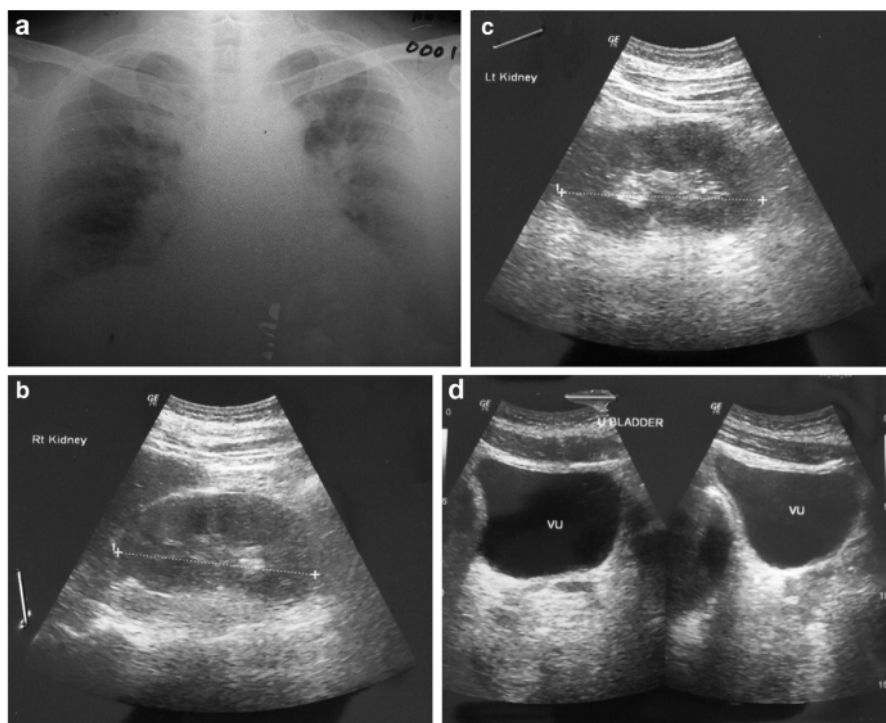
A chest radiograph showed fluid overload (lung edema) and renal ultrasound detected no evidence of abnormalities. (a) A chest x-ray showed lung edema. (b) The right kidney is normal. (c) The left kidney is normal. (d) The other organs, such as the bladder, are normal.
